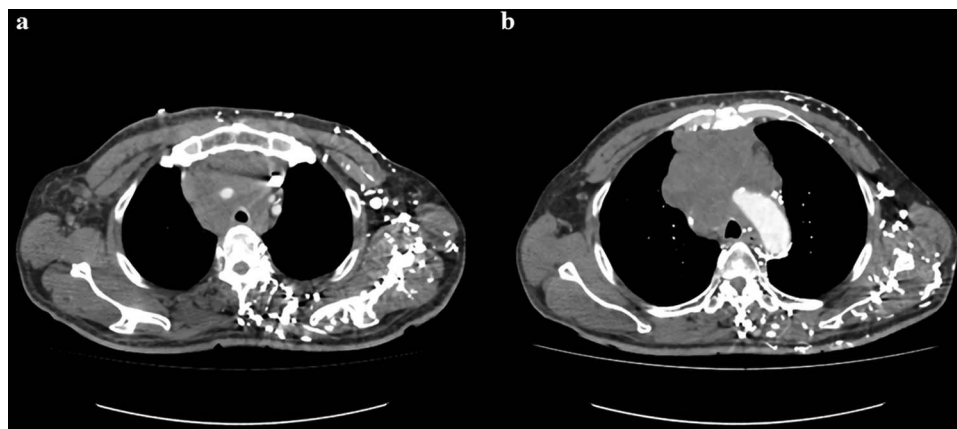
Chest CT showed mediastinal mass invading pericardium, superior vena cava and compressing trachea (a, b).
